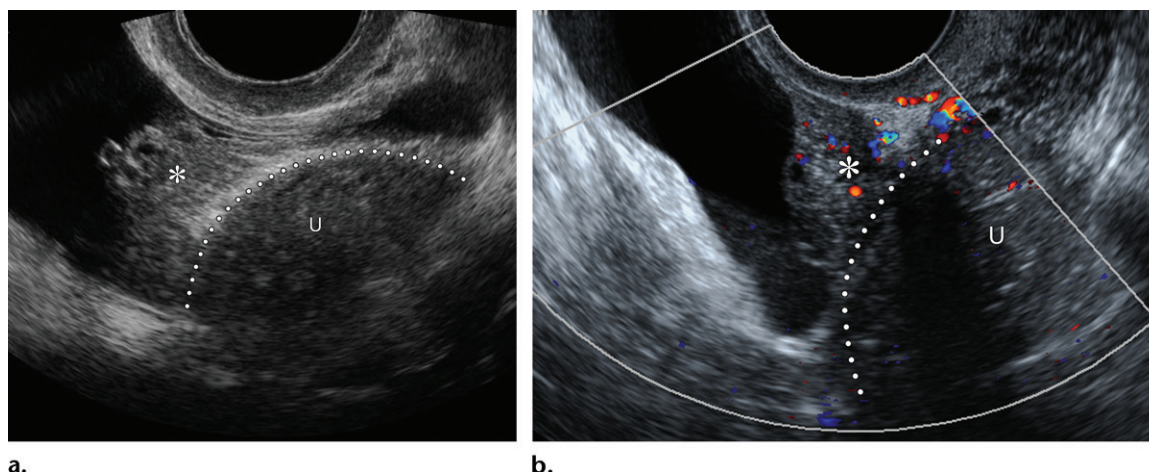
Bladder DIE in a 47-year-old woman with chronic pelvic pain and infertility. Endometriosis was confirmed at cystoscopy. Transverse gray-scale (a) and sagittal color Doppler (b) TVS images show internal cystic change in an endometriosis nodule (*) that involves the dome of the bladder wall and projects into the lumen. There is mild internal vascularity within the nodule, which is near the uterine fundus (U, dotted line).
